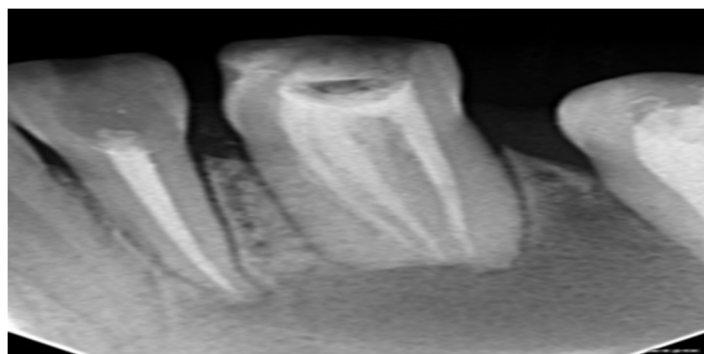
Periapical radiograph showing root canal obturation after 6 months follow up.
